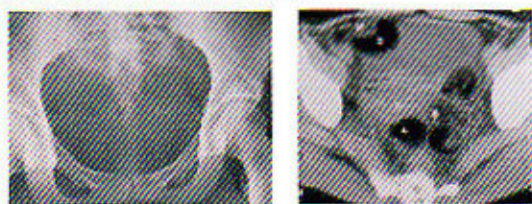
MRI of Pelvis - Mixed signal intensity areas on T1 and T2 images.
